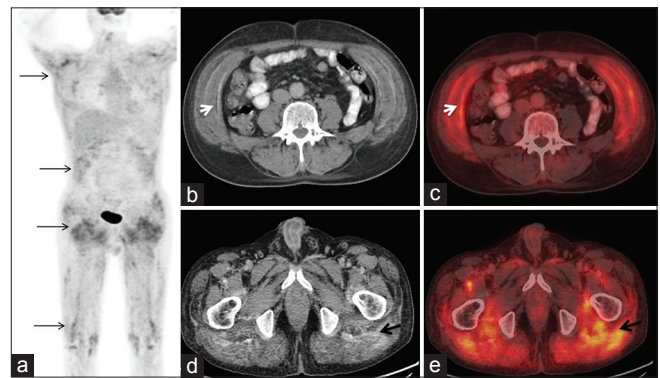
Maximum intensity projection image (a) shows increased fluorodeoxyglucose uptake in the muscles of shoulder, bilateral lateral abdominal wall, bilateral glutei, and in few muscles of bilateral thigh (multiple thin black arrows). Noncontrast transaxial computed tomography (b) and transaxial positron emission tomography/computed tomography (c) showing increased fluorodeoxyglucose uptake in the oblique muscles with hyperdensity (suggestive of calcifications) in the lateral abdominal wall muscles and along the fascial plane (white arrowheads). Transaxial computed tomography (d) and transaxial positron emission tomography/computed tomography (e) showing diffusely increased fluorodeoxyglucose uptake in the bilateral glutei muscles with areas of intramuscular hyperdensities (likely calcifications) (black arrowheads)
